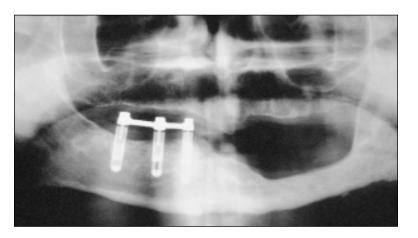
Orthopantomogram 4 years after prosthetic reconstruction.
